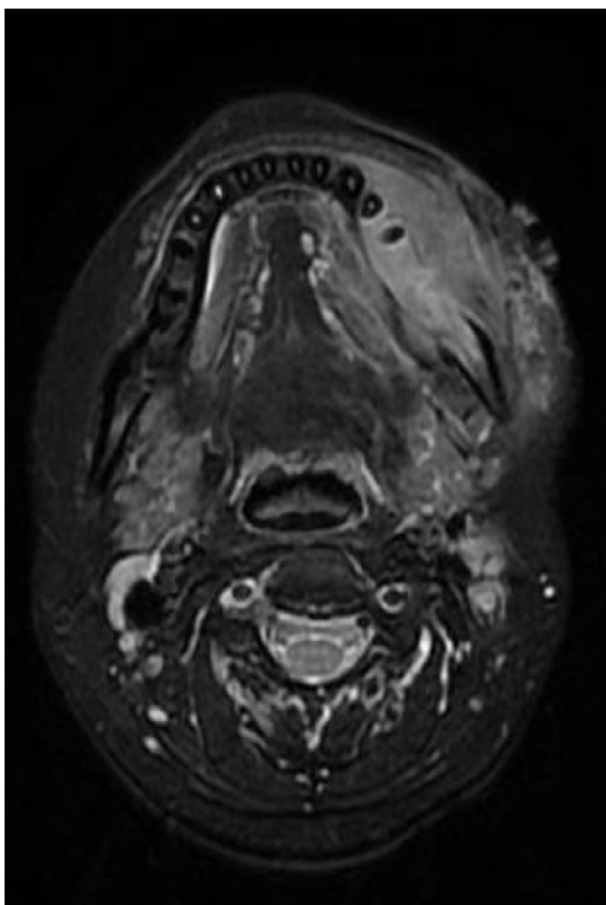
Axial MRI (T2 weighted).
